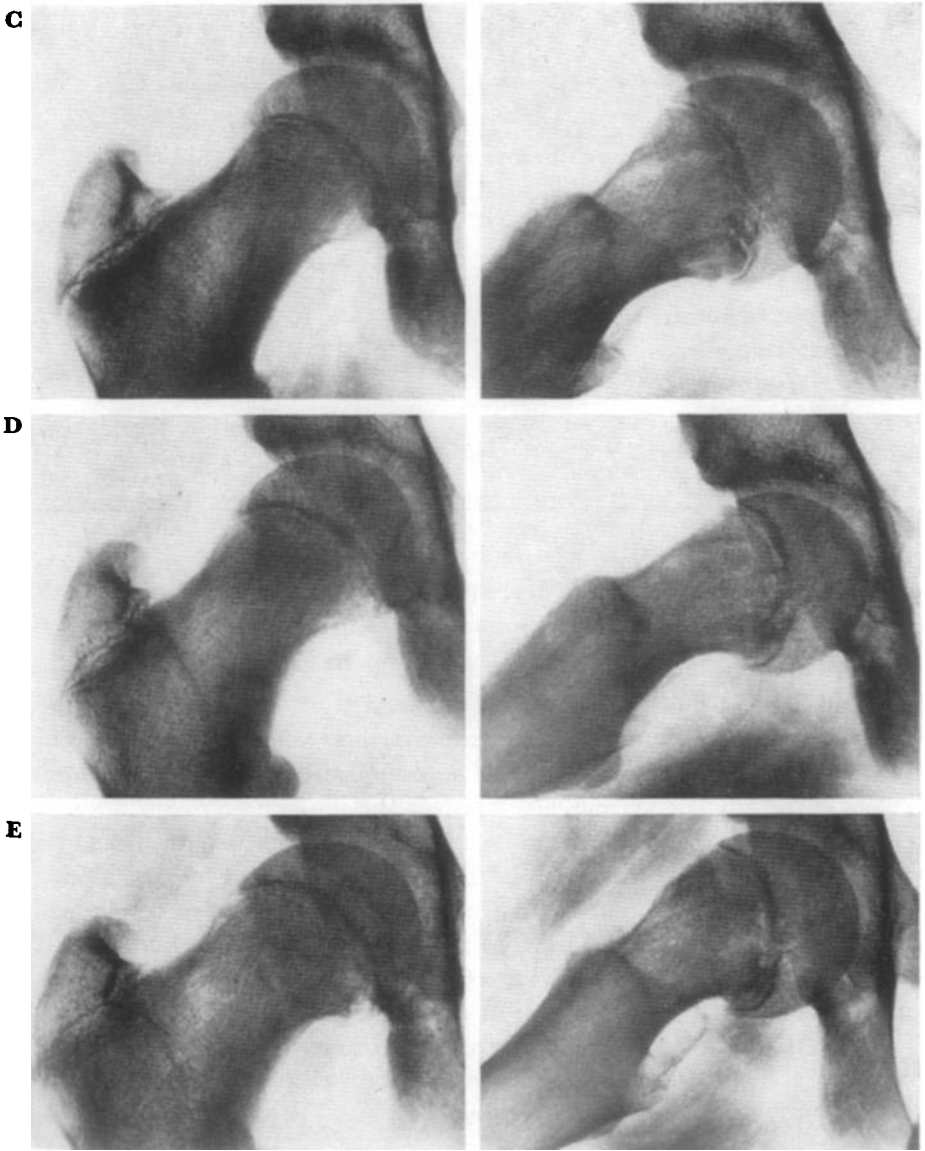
C. — Three months later. The epiphyseal line is more irregular in the lateral X-ray than in previous roentgenogram. The patient had no symptoms. This X-ray was taken at the same time as the control X-ray from the other, nailed hip.
